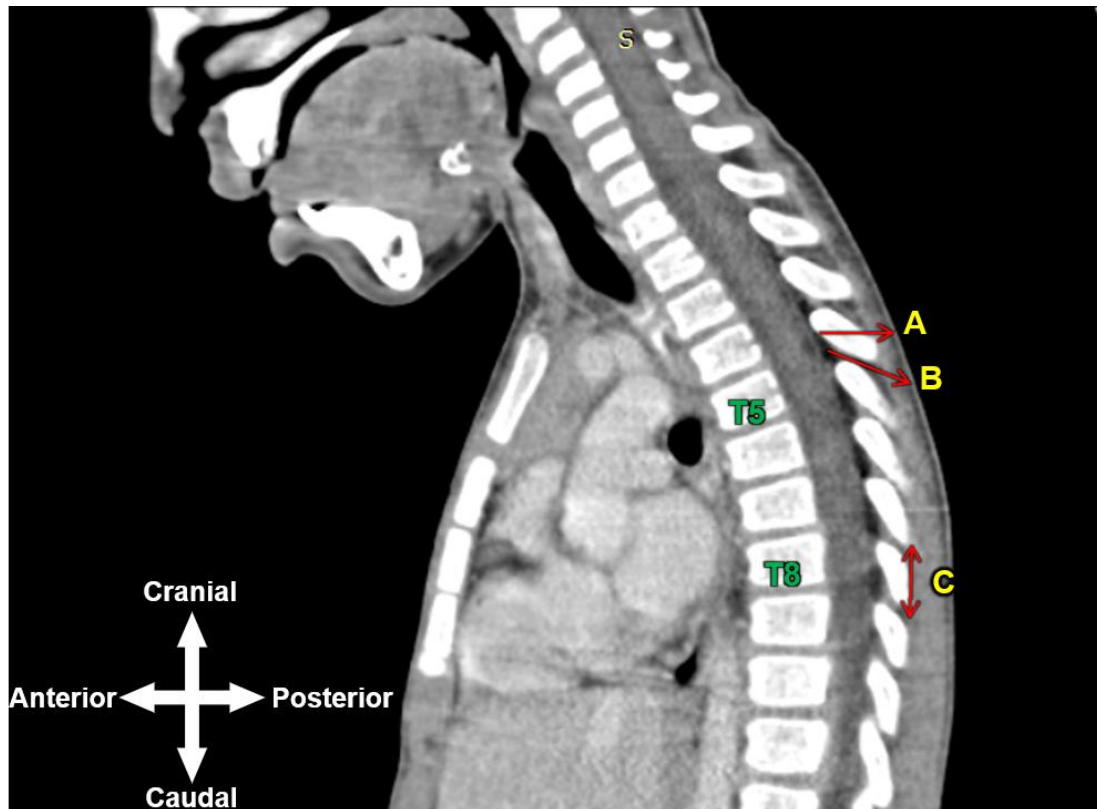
A CT scan of a sagittal section through the vertebral column. From this view, the 5th and 8th vertebral levels can be identified. Measurements taken: A – the distance from the skin to the anterior border of the ligamentum flavum; B – the distance from the skin to the anterior border of the ligamentum flavum at an incline; C – the distance from the inferior border of the upper spinous process of the interspinous space and the superior border of the lower spinous process.
